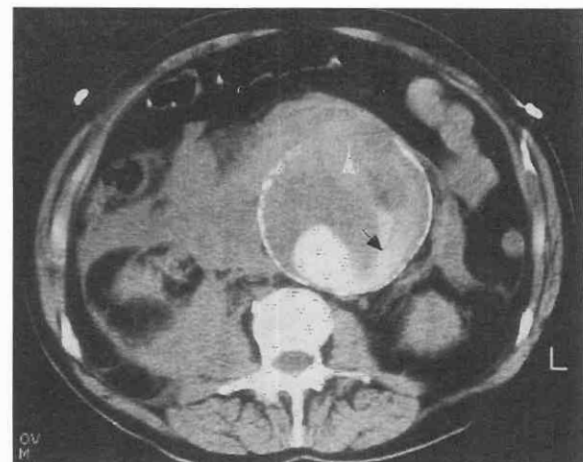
Ruptured abdominal aortic aneurysm. Contrast-enhanced CT scan demonstrates active intravasation of blood into the extensive aneurysm thrombus (black arrow). Blood is also extravasating into the retroperitoneum through a large defect in the anterior wall of the aorta (white arrowhead). Disruption of the aortic calcification can be seen.
